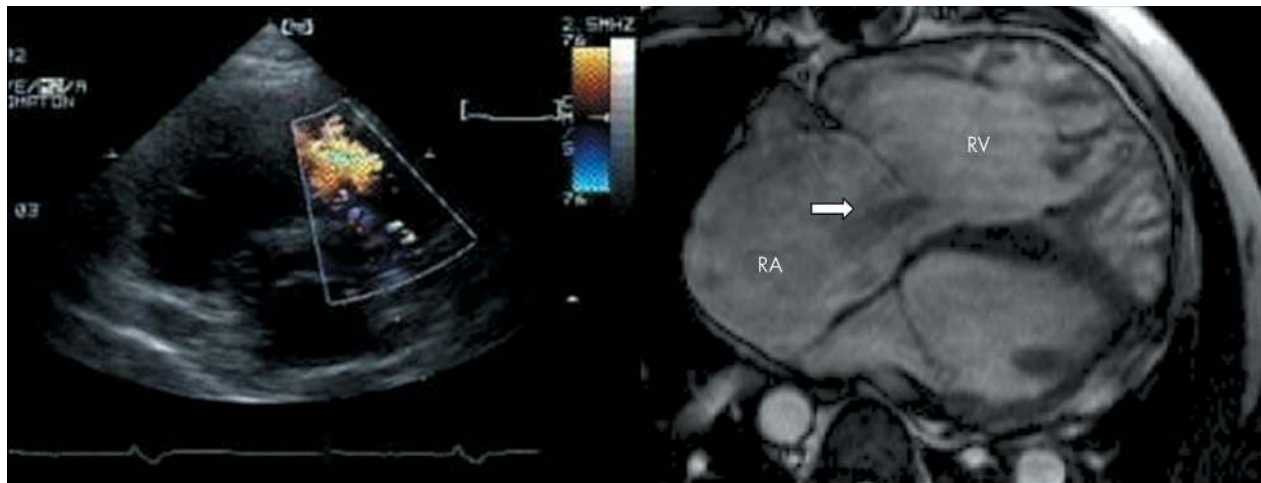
Left panel: Echocardiographic colour flow mapping (short axis left parasternal view), showing a pulmonary valve regurgitation jet. Right panel: gradient echo (white blood) cardiac magnetic resonance (CMR) sequence of the same patient, four chamber transaxial (short axis of the thorax) view. There is severe right atrioventricular dilatation and RV hypertrophy. Tricuspid regurgitation is depicted as signal void (black coloured jet of blood) at the level of the tricuspid valve towards the right atrium (white arrow). RA, right atrium; RV, right ventricle.
